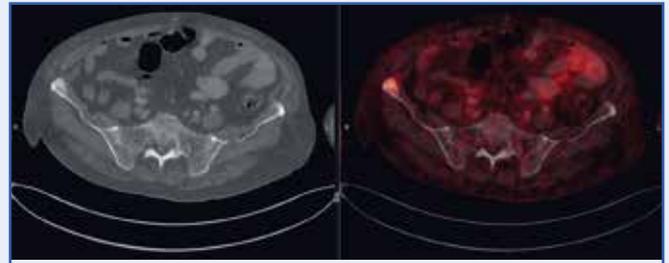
Ga-68 PSMA PET-CT distinctly displays moderate PSMA uptake in the right iliac bone and D8 vertebral lesions determining that the metastases are from the prostatic second primary rather than the bladder tumor.
